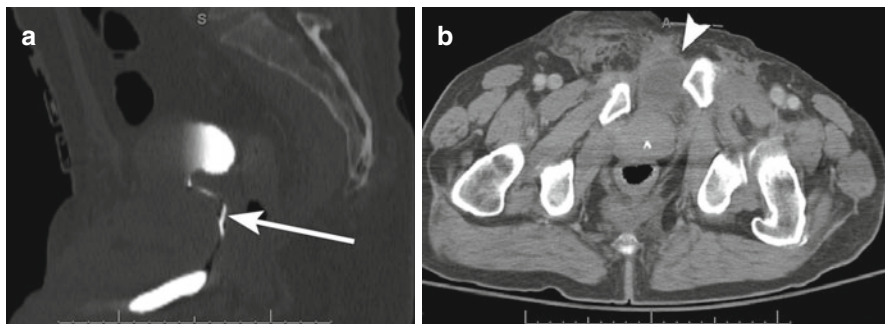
A 74 year-old male presents after sustaining pelvic trauma. (a) Sagittal image of the pelvis during the excretory phase shows contrast filling the urinary bladder and stretching of the urethra (*arrow*), but no extravasation of contrast (type II injury). (b) Axial computed tomography (CT) image shows traumatic bladder extrophy (*arrowhead*) and diastasis of the pubic symphysis
